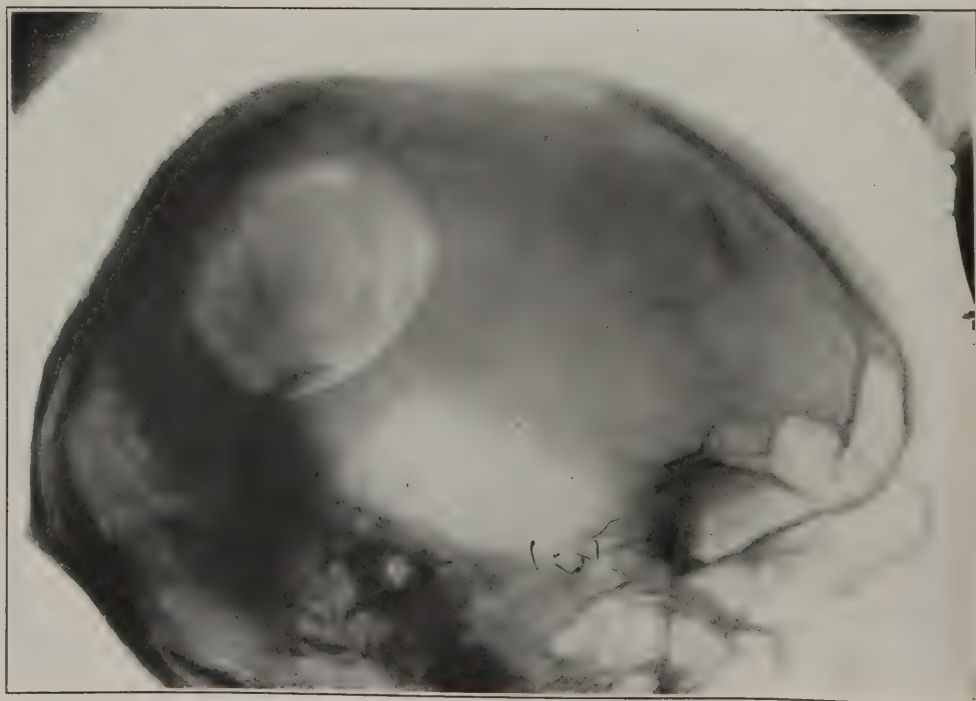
Roentgenogram of head shown in Figure 39, after autogenous cranial transplant
